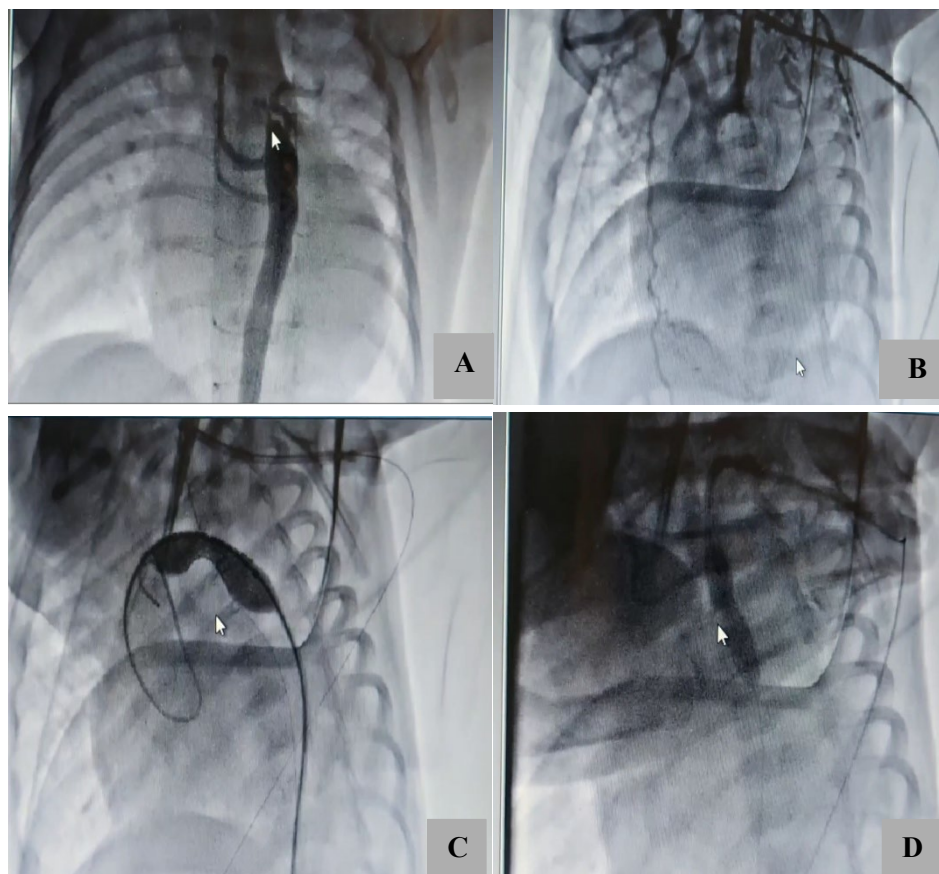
Procedural images of a 2-month-old infant with coarctation of the aorta (CoA) and a hypoplastic aortic arch. (A) Pre-procedural CT angiography demonstrating discrete CoA with a hypoplastic arch (arrow). (B) Intra-procedural fluoroscopy showing balloon angioplasty via axillary access for concurrent aortic narrowing, followed by (C) deployment of a 4 mm Blue Palmaz stent (Cordis, USA) using a balloon-expandable technique. (D) Post-procedural angiography confirmed stent patency and a residual gradient of 4 mmHg. This case demonstrates the feasibility of axillary access and staged intervention in infants with complex coarctation of the aorta (CoA) anatomy
